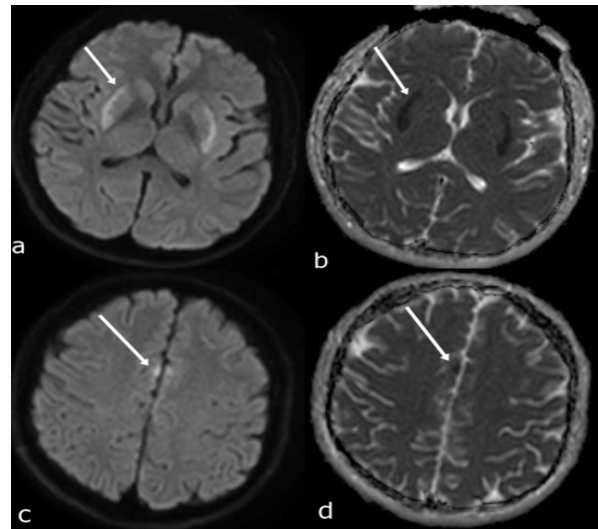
MRI shows marked diffusion restriction (arrows) which appears hyperintense in DW image and suppressed in ADC at the both putamens (a,b) and cingulate gyri (c,d).
